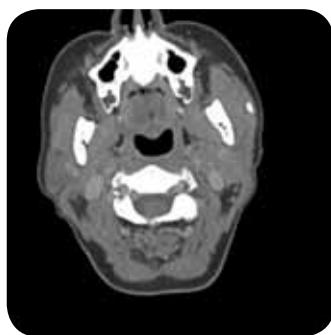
Axial CT, soft-tissue window, without contrast showing ovoid radiopacity consistent with sialolith in the main duct of the left parotid, which is enlarged compared to the right side. Patient's right side is on left side of photo. (Image courtesy of Todd Stultz, MD, DDS, Cleveland, Ohio.)
